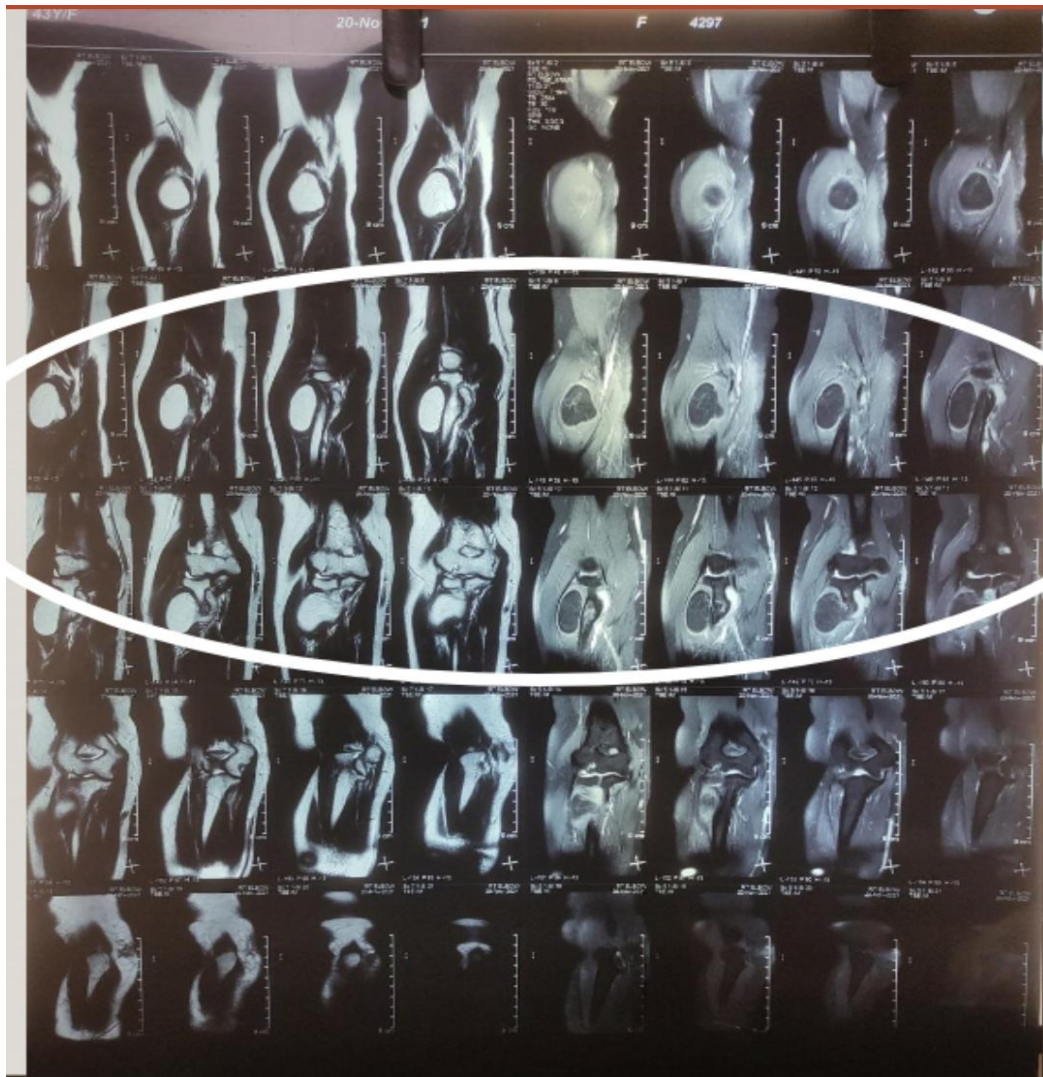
MRI of the proximal forearm showing the lesion encircling the radius bone.
